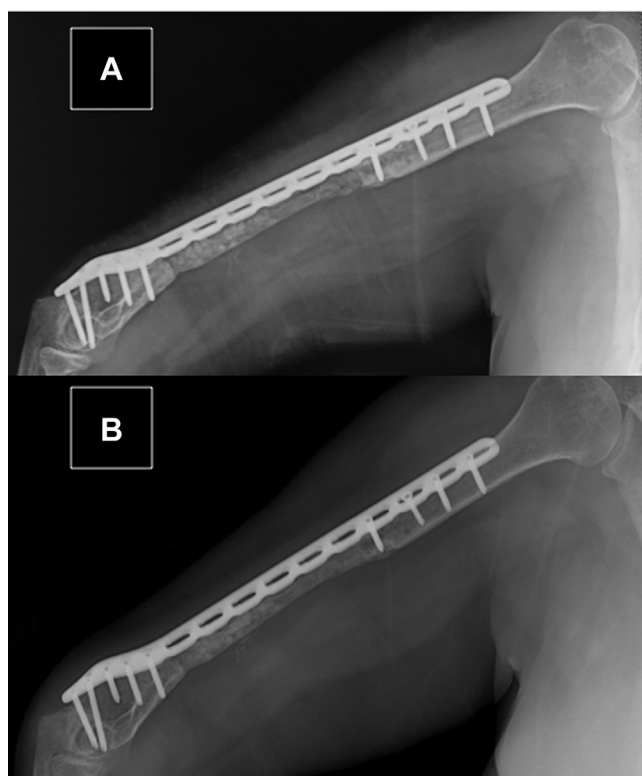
Follow-up radiographs after stage 3: (A) 2 months; (B) 5 months.
